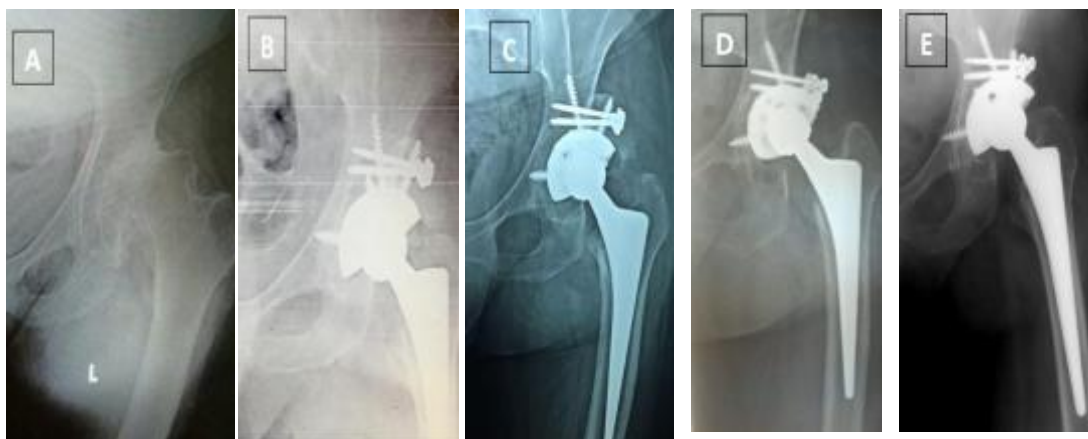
Female case, 65 years old with left acetabular dysplasia (A) Preoperative x-ray examination, (B) Immediate postoperative x-ray, (C) Radiological follow up after 2 weeks, (D) after 3 months and (E) after a year.
